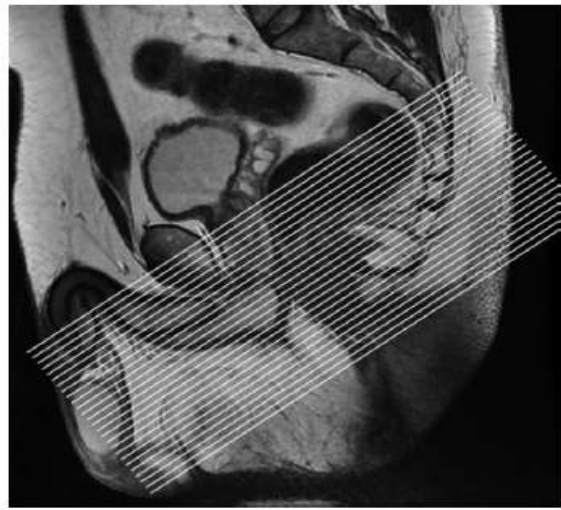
Suggested orientation for axial MR imaging of the anal canal. Sagittal T2-weighted image through the midline is used to obtain images that are truly axial relative to the anal canal.
